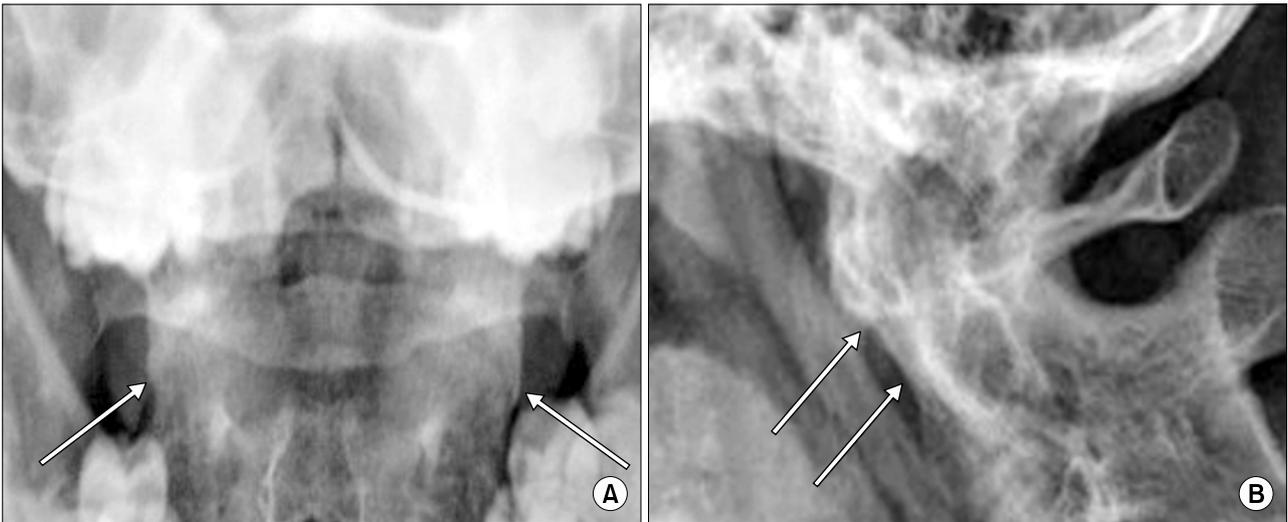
(A) A 31-year-old ankylosing spondylitis patient with duration of 9 years. An anteroposterior open-mouth view of the cervical spine shows obliteration of atlantoaxial facet joints (arrows, component II). (B) A lateral radiograph of the cervical spine with full flexion of the same patient shows bony ankylosis of the atlantoaxial joint space and ankylosis of anterior longitudinal ligament (arrows, component I and III).
